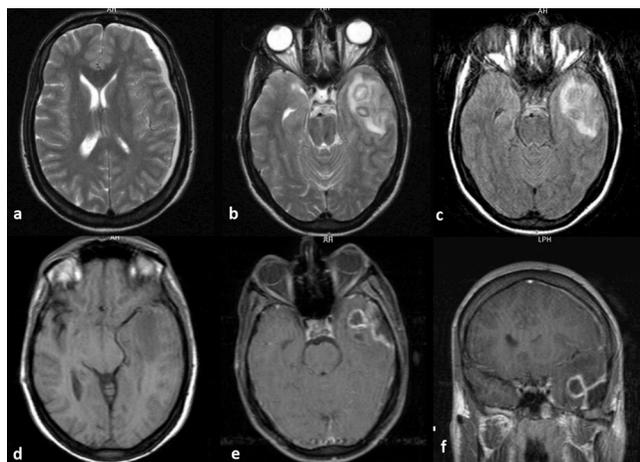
In the preoperative cranial MRI, extraaxial empyema in the left side causing compression to the left lateral ventricle in the axial T2 weighted sequence (a), two hyperintense lesions in the left temporal lobe with a hypointense rim of peripheral edema suggestive of abscess (b) are observed. In axial FLAIR sequence the lesions in the left temporal lobe are hypointense with peripheral edema (c). In the axial T1 weighted sequence hypointensity is seen in the temporal lobe (d), while hypointense lesions with peripheral contrast enhancement and dural contrast enhancement are detected in postcontrast axial (e) and coronal (f) sequences.
